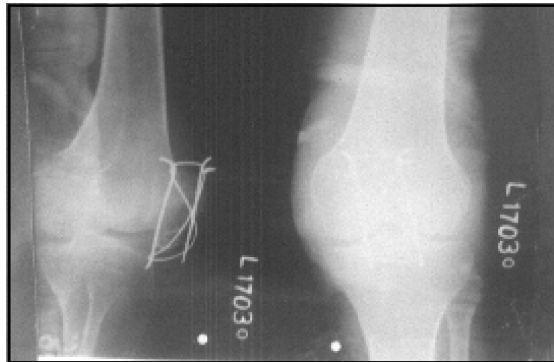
Post-op X-ray of following tension band wiring.
